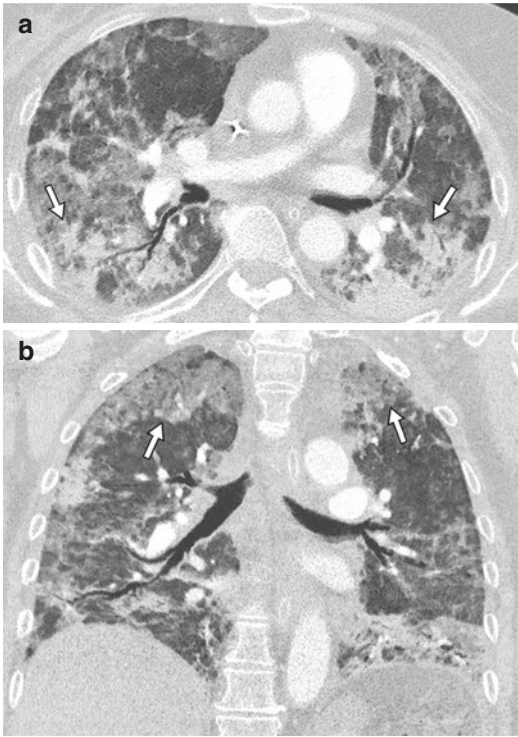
Idiopathic pneumonia syndrome in a 63-year-old woman with diffuse large B-cell lymphoma. (a) Axial and (b) coronal CT scans showing bilateral patchy areas of consolidation and ground-glass opacities (arrows)
